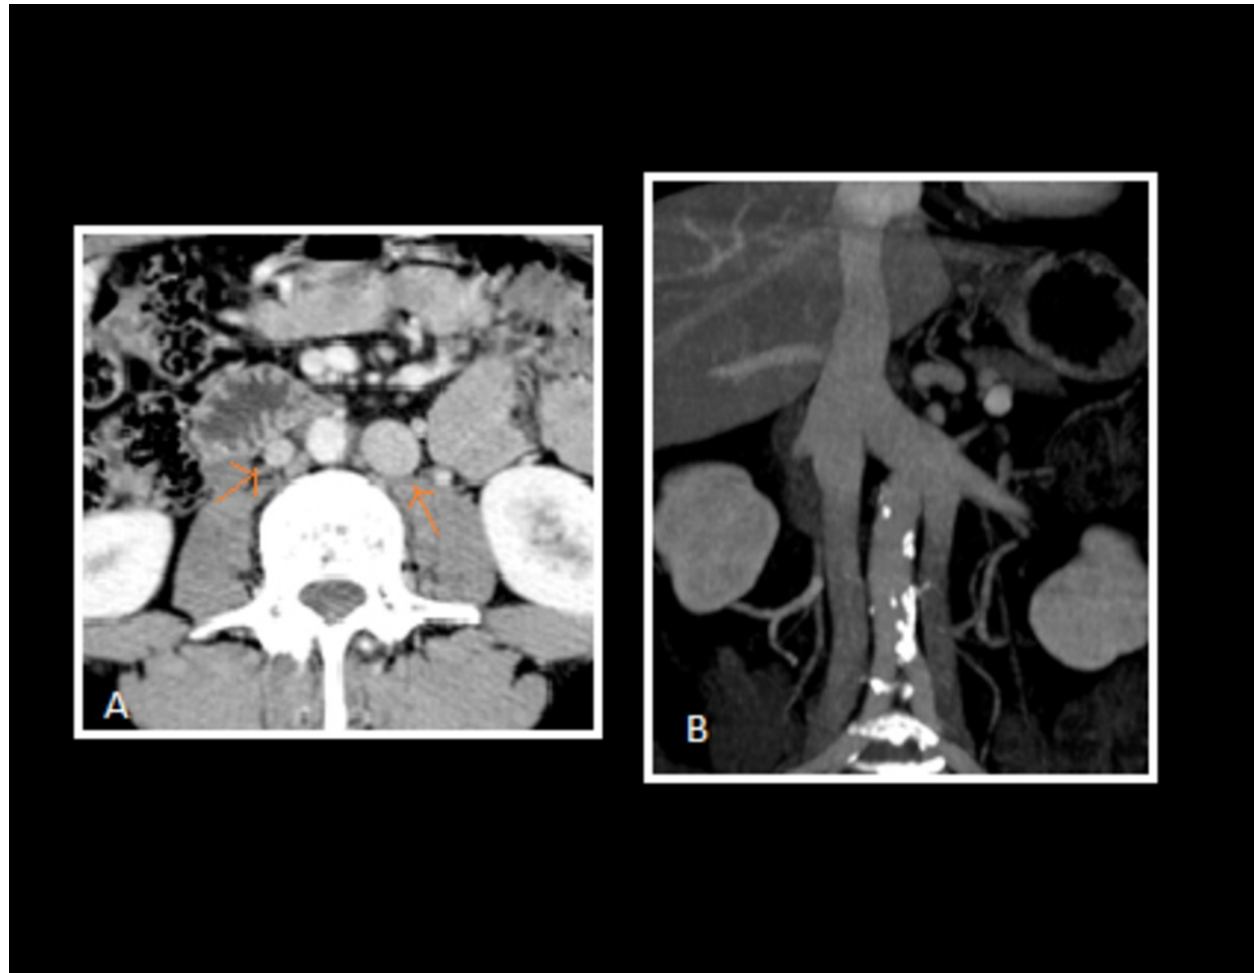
Double IVC. Contrast enhanced CT (A) shows right and left infrarenal IVCs (orange arrows). The coronal computed tomography (B) shows the left IVC opening into the left renal vein, which crosses anterior to the aorta to form a single right-sided suprarenal IVC.
